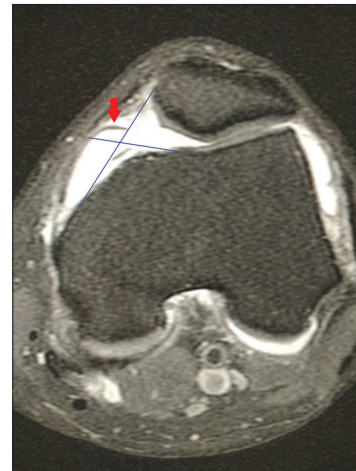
Axial fat-sat spin-echo proton density (3000/50) magnetic resonance image demonstrate a thin, hypointense line (arrow) originating from the medial wall of the left knee joint consistent with mediopatellar plica (Sakakibara type B). Intersection point defining the point X
